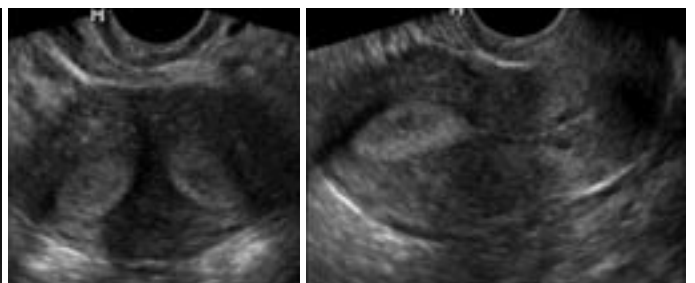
Vaginal ultrasound study was suspicious for an arcuate or septated uterus.
